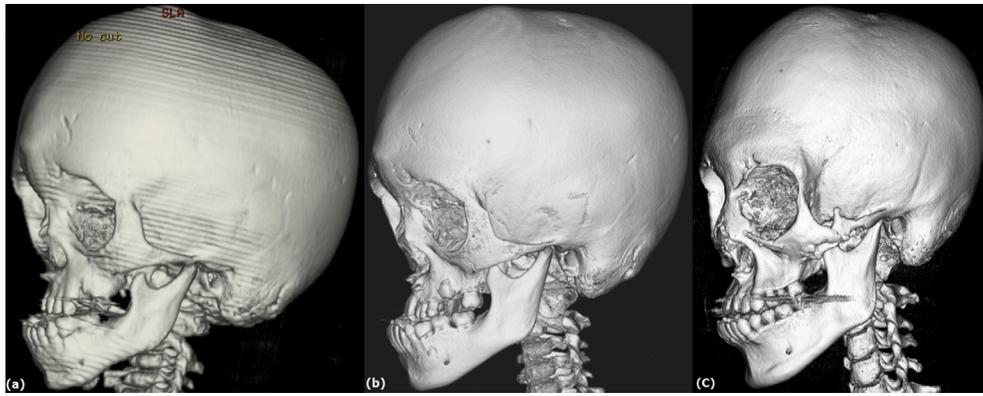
Case presentation. (a) Initial CT scan demonstrating favorable head shape and the pan-craniosynostosis without a definite beaten copper phenotype. (b) Preservation of a favorable head shape without presentation of increased ICP until 8 years of age. (c) Postoperative view demonstrating excellent mid-facial shape at the 8-year follow-up visit after Le Fort III osteotomy and distraction osteogenesis.
